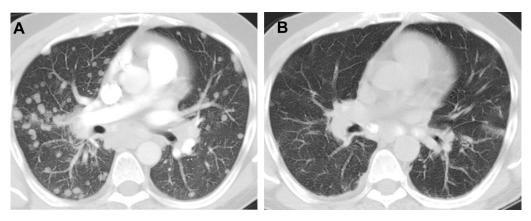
(A) Axial CT 4 years before current admission showed numerous bilateral noncalcified pulmonary nodules and (B) CT chest at the time of admission demonstrating interval resolution.
